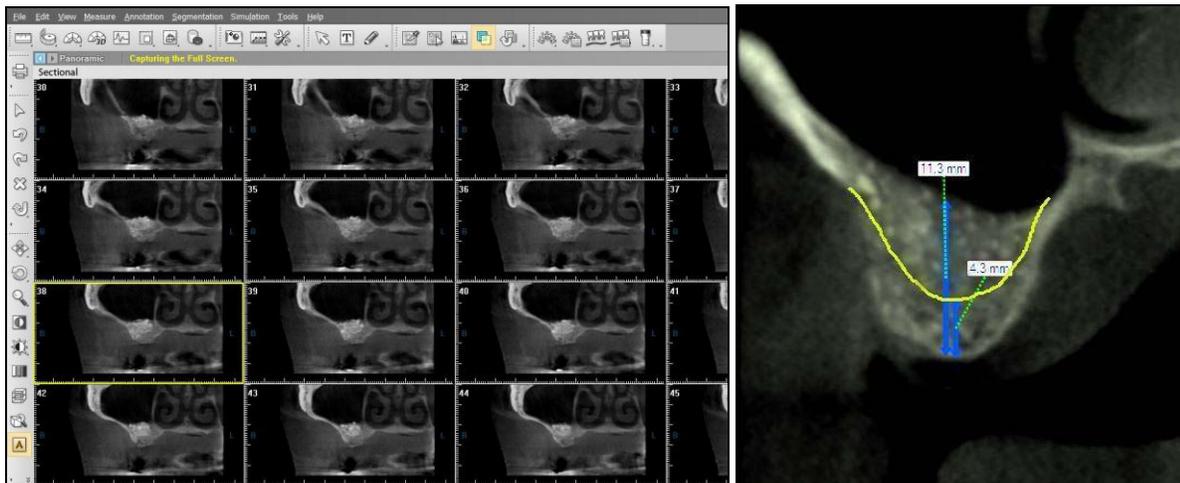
Cone-beam CT scan after 6 months from sinus augmentation.
